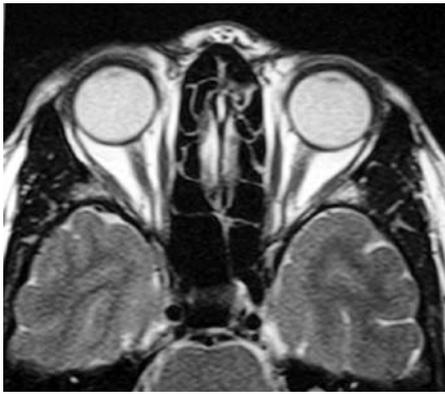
Axial T1-weighted orbital MRI, shows edema-like change, and enlarged left optic nerve sheath.
